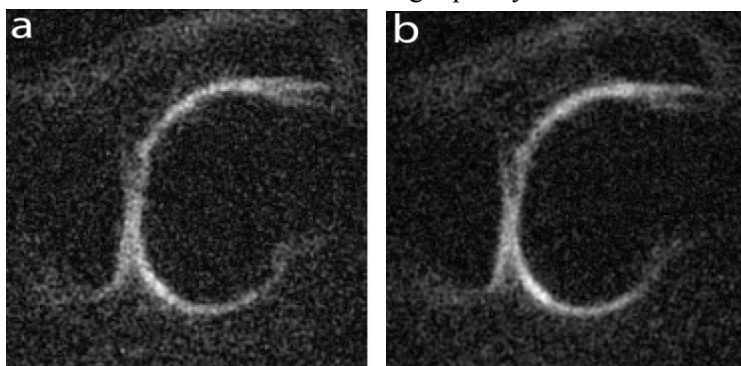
Sodium MRI of the knee using (a) TSC parameters (flip angle=89°, TE/TR = 0.120/90 ms, 1 average) (b) PASS parameters (flip angle=74°, TE/TR = 0.185/30 ms, 3 averages). Scan times are equivalent at 9 minutes each
